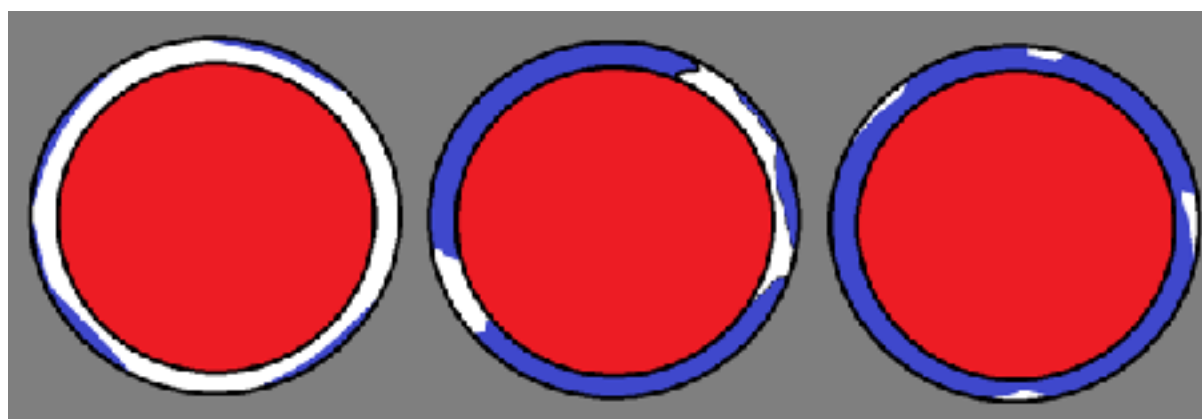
Patterns of aortic wall calcification. On noncontrast-enhanced computed tomography (CT) scans is possible to visualize these patterns of calcification: (right) circumferential calcification in a patient with radiation-associated cardiovascular disease, (middle) more confluent calcification in a patient with a remote history of aortitis and (left) patchy calcification typical of atherosclerosis.
